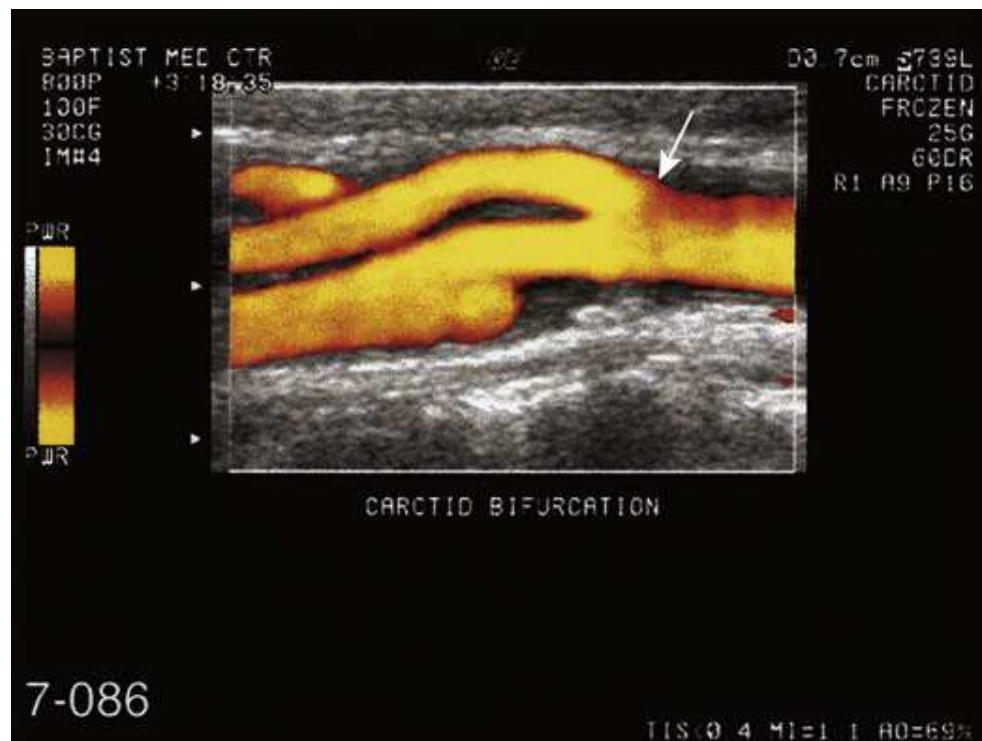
Sagittal sonogram of carotid artery and bifurcation (*arrow*) into internal and external carotid arteries.
